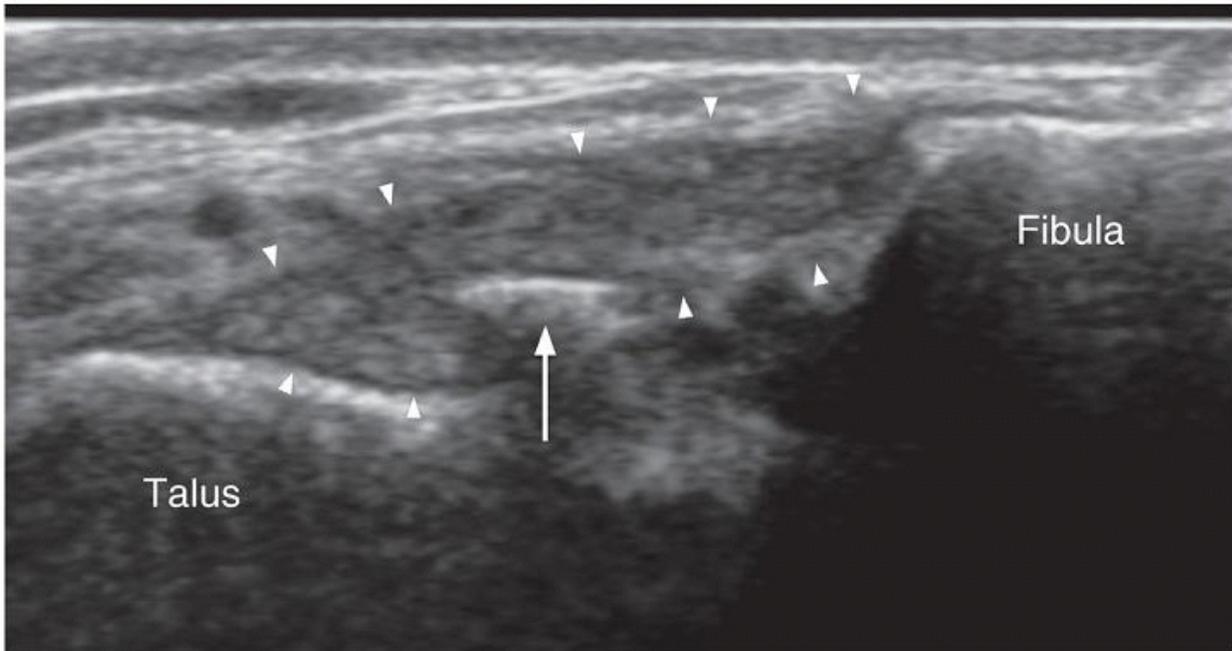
Longitudinal ultrasound anterolateral aspect of ankle. There is a healing tear of the ATFL with moderate ligament thickening (arrowheads) and a small avulsion fracture (arrow) most likely from the fibular tip. Overall, ligament continuity is maintained.
